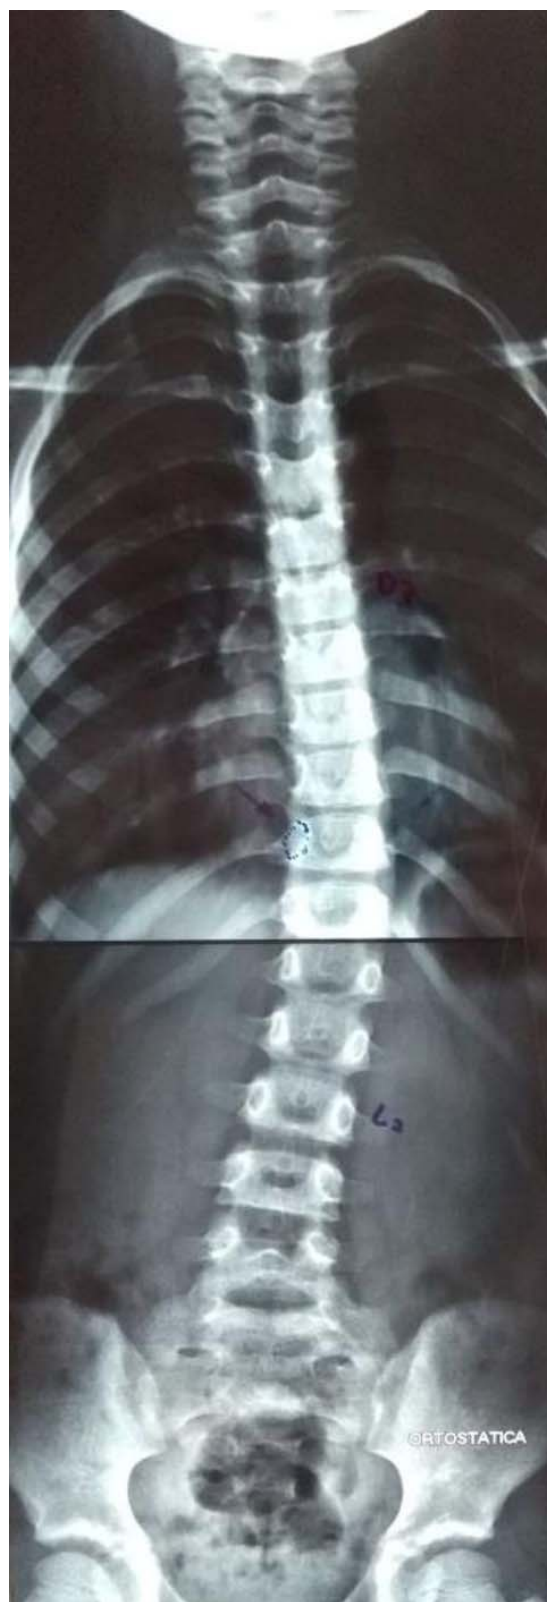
Panoramic radiography. The image shows dextrochondral scoliosis with a 20° Cobb angle.
